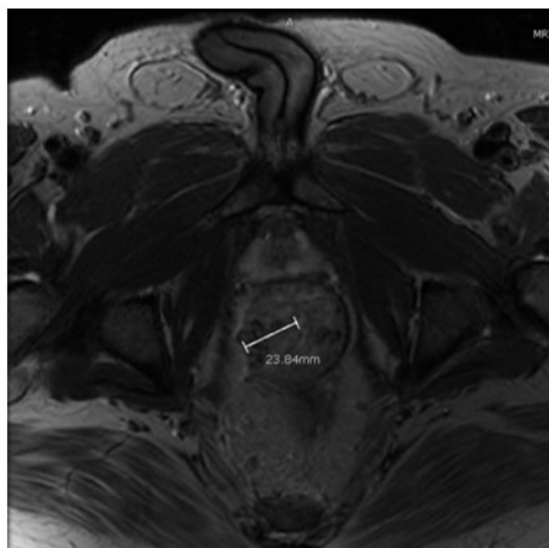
Magnetic resonance imaging (MRI) Pelvis revealing circumferential wall thickening of the inferior rectum measuring up to 2.4 cm in diameter with associated enhancement.
